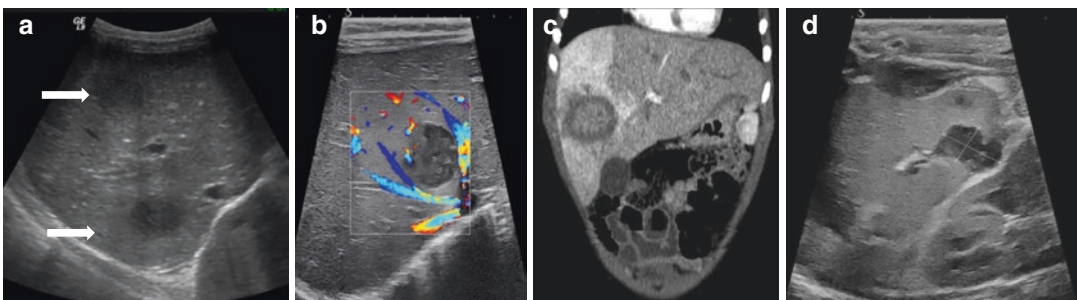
Liver abscesses: 4-year-old girl presenting with acute abdominal pain and fever. (a) Initial US examination shows two hypoechoic rather well-defined hepatic nodules consistent with liver abscesses in the context. (b) Color Doppler demonstrates patency of the surrounding vessels. (c) CE-CT shows a well-defined isoattenuating central area with a hypoattenuating appearance of its peripheral wall (target-appearance). Note the associated
